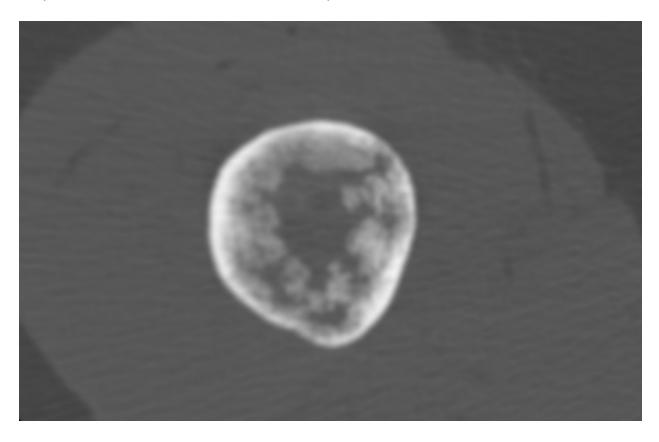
Fibrous dysplasia. Axial computed tomography reformation image (B) of the same patient in figure 1.
